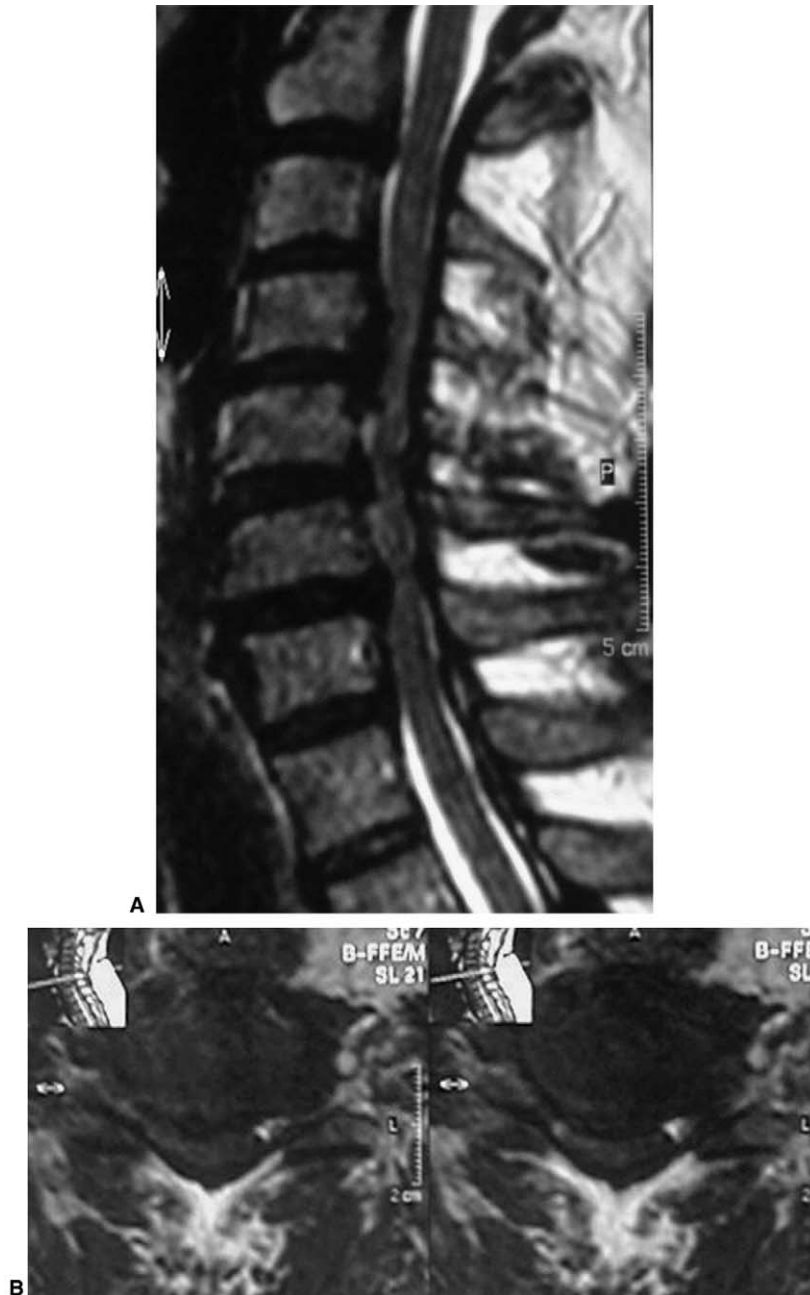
T2-weighted sagittal (A) and axial (B) MRI scans of the cervical spine of a typical patient presenting with myelopathy and circumferential spinal cord compression due to spondylotic disease. At several levels, cerebrospinal fluid is not visualized anterior to the spinal cord.
